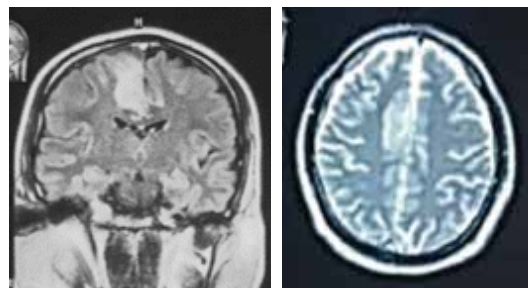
MRI brain plain.
